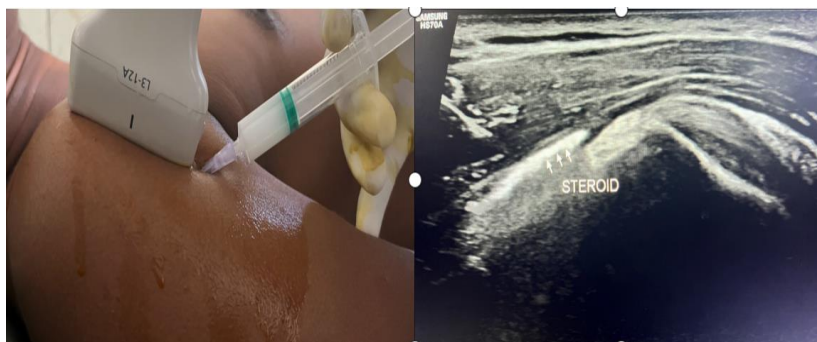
Image Showing Ultrasound Guided Steroid Infiltration
